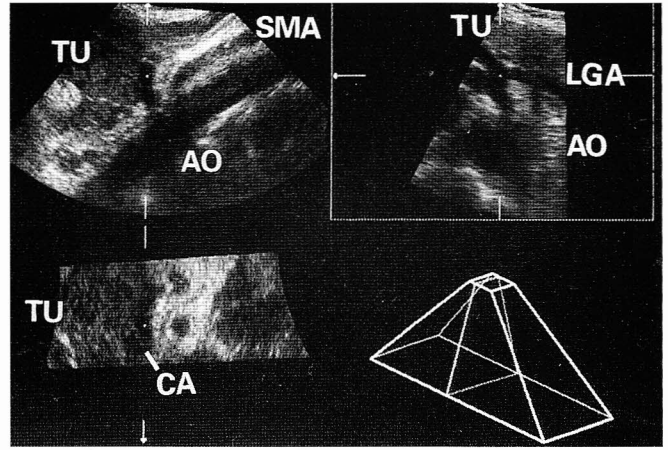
Abdominal 3-D ultrasound of a pancreatic carcinoma (Section display). (Tu= Tumor, Pa=Pancreas, Ao=Aorta, SMA= superior mesenteric artery, CA= coeliac axis, LGA=left gastric artery)
